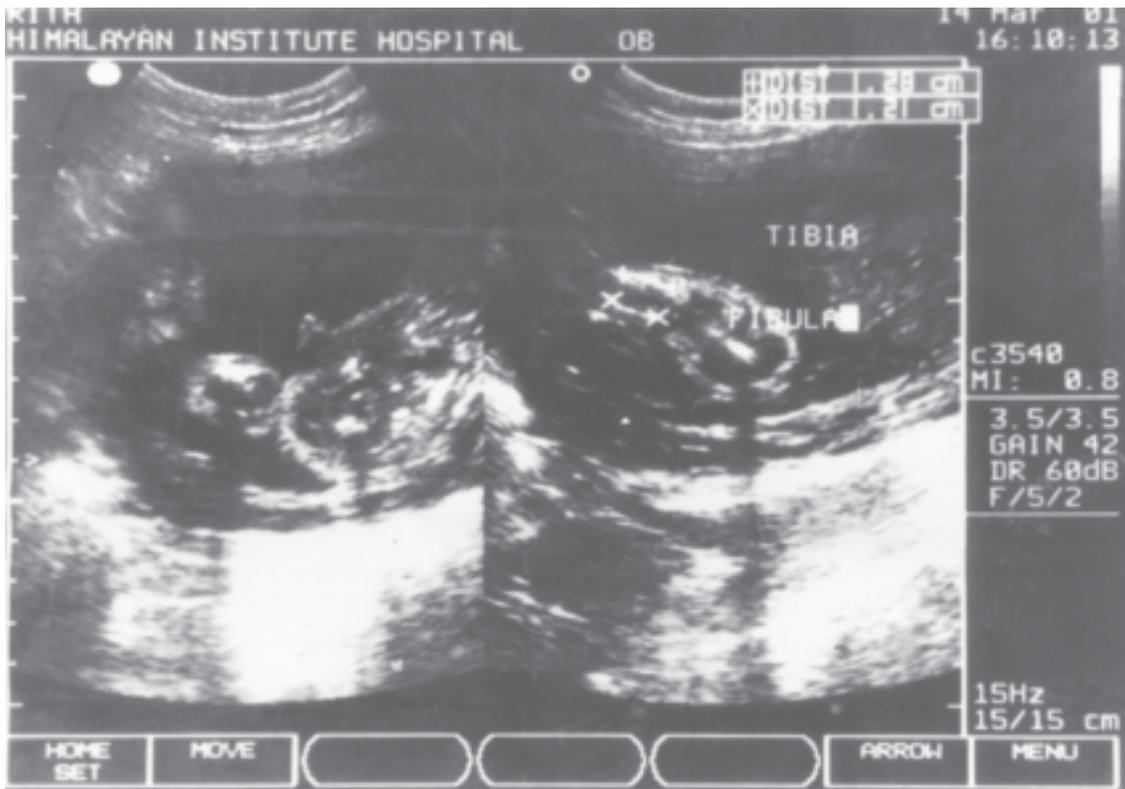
Ultrasonographic image showing diminished fibula.
